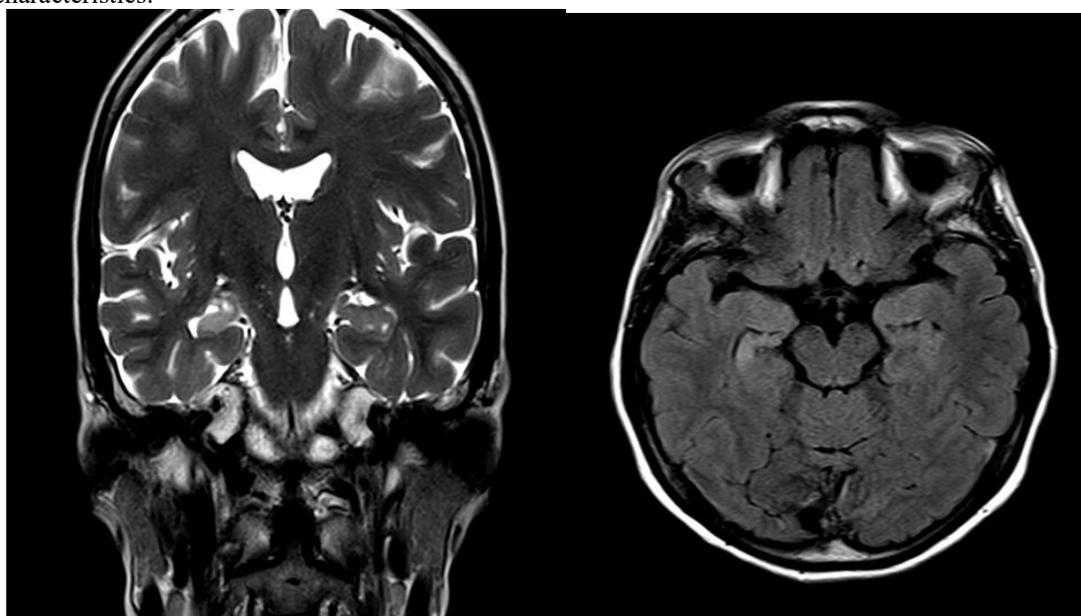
Coronal T2W, Axial FLAIR of MRI brain showing Right Mesial Temporal Sclerosis.
